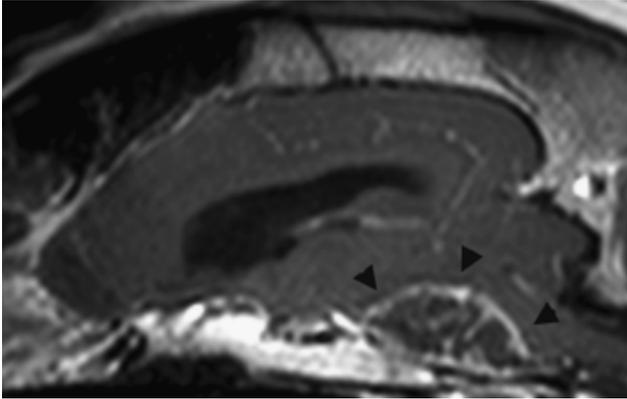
Sagittal T1-weighted postcontrast image. A thin, moderately contrast enhancing rim is present around the hypointense mass (arrowheads). A patchy contrast enhancing appearance with marked heterogeneity is seen (postcontrast T1W-TSE, TR = 600 ms, TE = 10 ms, slice thickness = 2 mm, interslice gap = 1 mm, FOV [sagittal] = 18 × 18 cm, matrix acquisition [sagittal] = 200 × 161).
